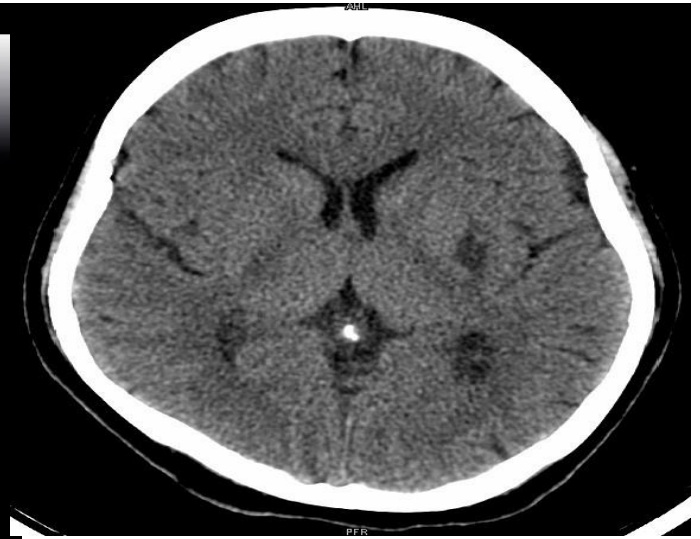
CT head showing an acute infarct in the lentiform nucleus of the left basal ganglia.
